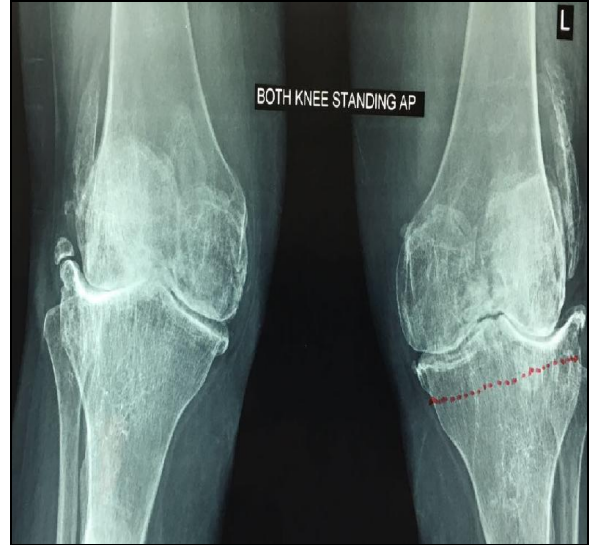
Pre-operative x-ray AP view of both knee joints
